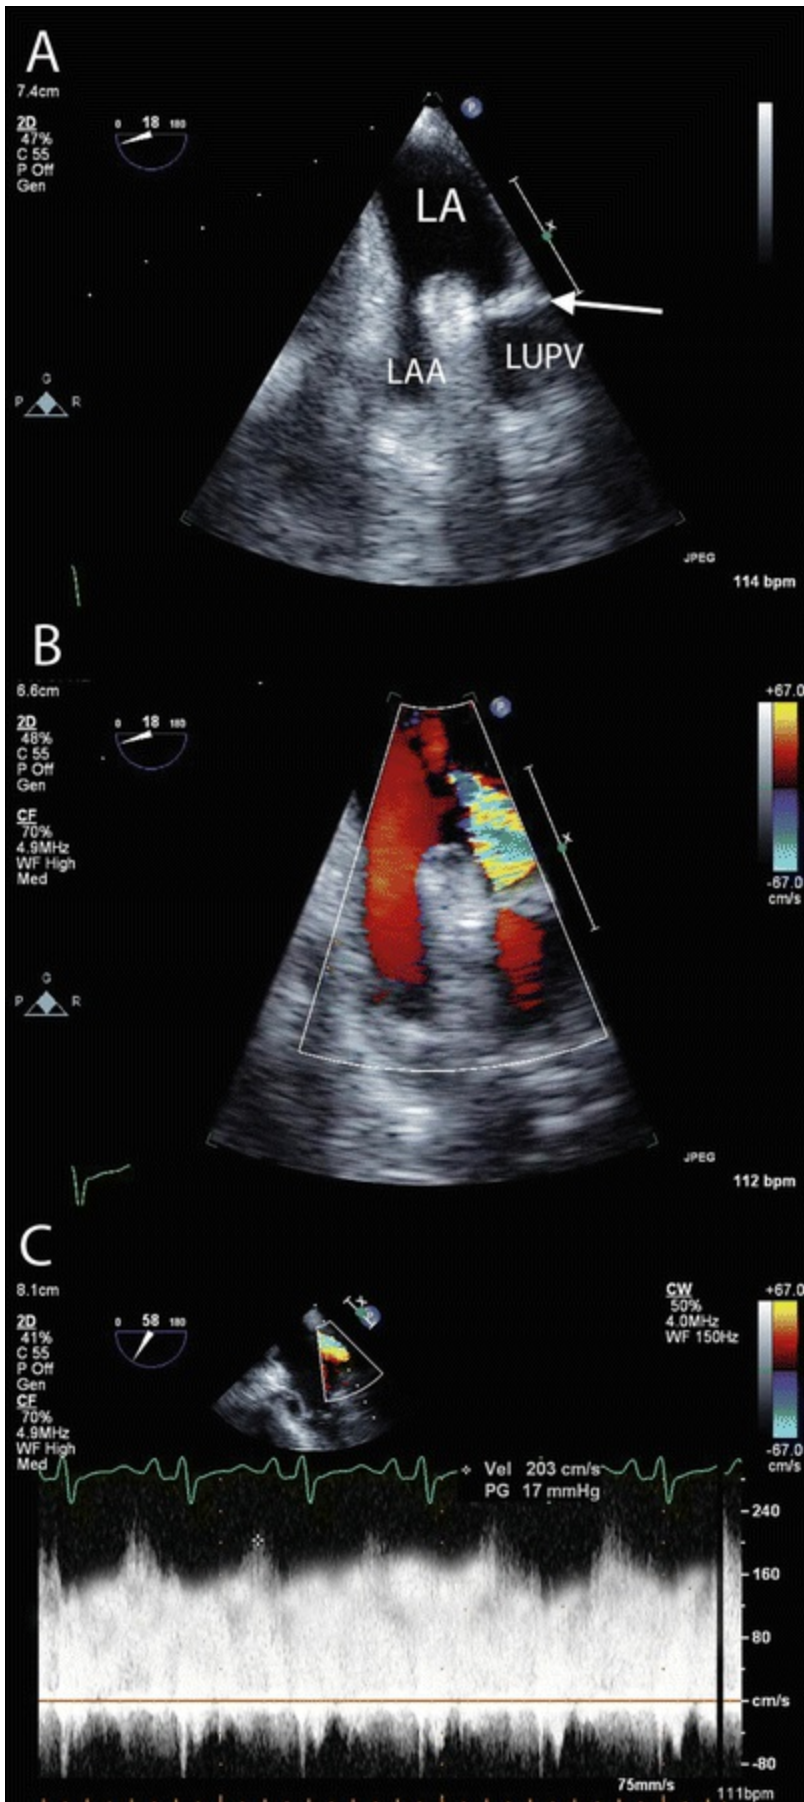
Pulmonary venous obstruction . (a) TEE imaging of the left upper pulmonary vein and left atrial appendage demonstrating obstruction (*arrow*) within the pulmonary vein. (b) Color Doppler imaging demonstrating turbulent flow at the site of obstruction. Flow in the pulmonary veins is normally laminar (similar to the flow in the adjacent atrial appendage). (c) Pulsed Wave Doppler imaging demonstrating increased velocity (203 cm/s) and loss of the normal phasic flow pattern within the pulmonary vein. The normal peak velocity of blood flow in the pulmonary veins is <1 m/s. LA left atrium, LAA left atrial appendage, LUPV left upper pulmonary vein
